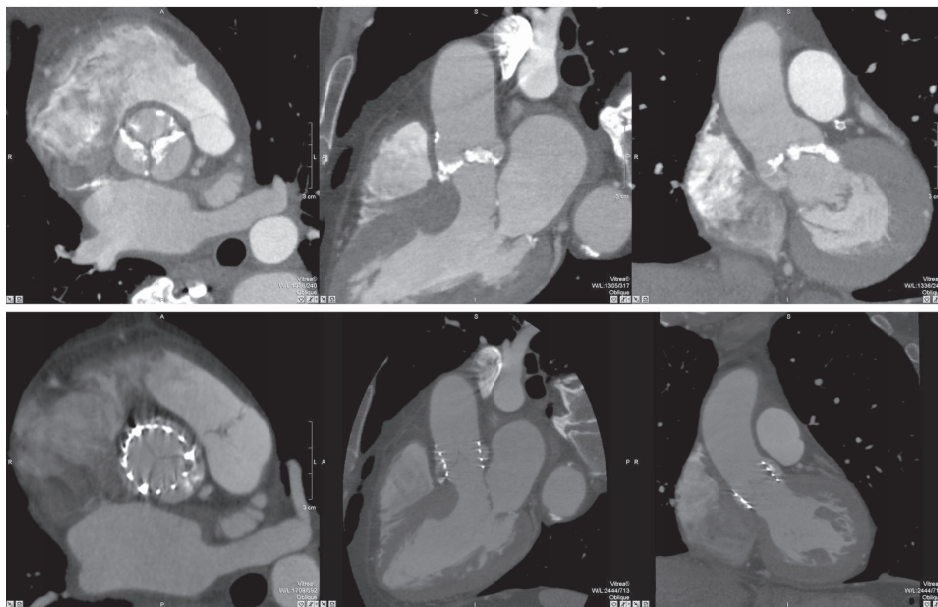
Multi-slice computed tomography of the aortic valve (AV) in a patient referred for percutaneous AV replacement, in an axial (left panel), sagittal (middle panel) and coronal view (right panel). In the upper panel the extensive calcifications of the native AV are well visualized. The lower panel clearly demonstrates the location of the AV prosthesis (Edwards SAPIEN valve).
